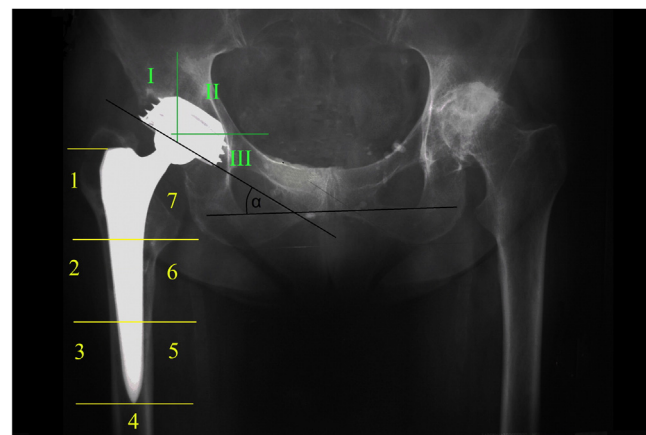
Anteroposterior radiograph of the pelvis with both hips. Distribution of osteolysis according to the zone of DeLee and Charnley [12] and Gruen [13], with an abduction angle (α) of the cup.
